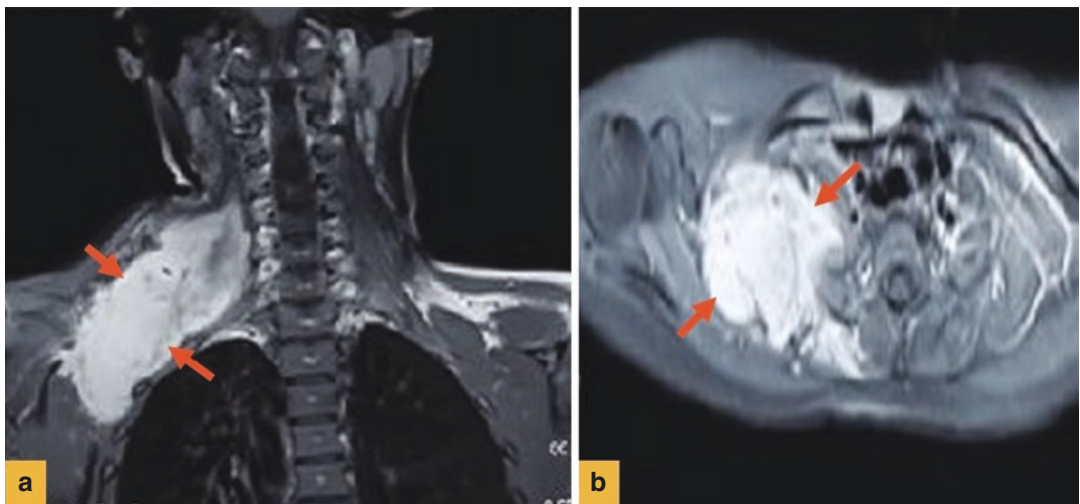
(a, b) An enhanced tumour mass on the MRI with irregular border and mild heterogeneity. This is consistent with a fibromatosis
